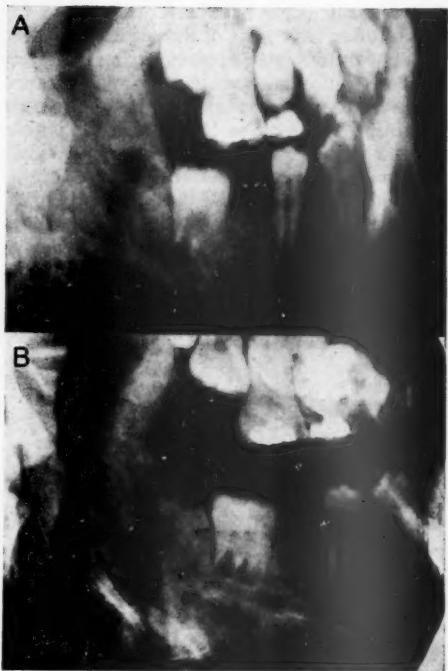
A, an oblique lateral jaw radiograph taken with medical X-ray equipment and using screen-sensitive film. B, a radiograph of the same patient using a carefully coned beam and non-screen film. The exposure is no more than for a medium-speed periapical film. With the latter technique the small trabeculae of woven bone and the thin cortex are apparent, making a diagnosis of fibrous dysplasia of bone possible. A periapical radiograph with its finer grain would add more certainty to the diagnosis*
